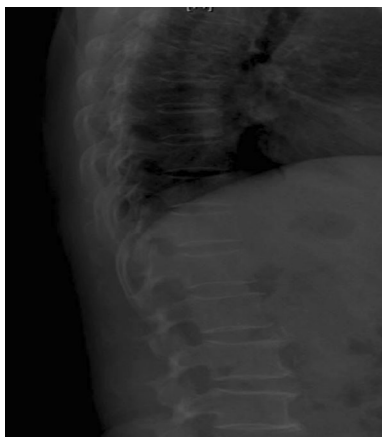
X-ray of the thoraco-lumbar spine showed diffuse osteopenia and osteophytes
